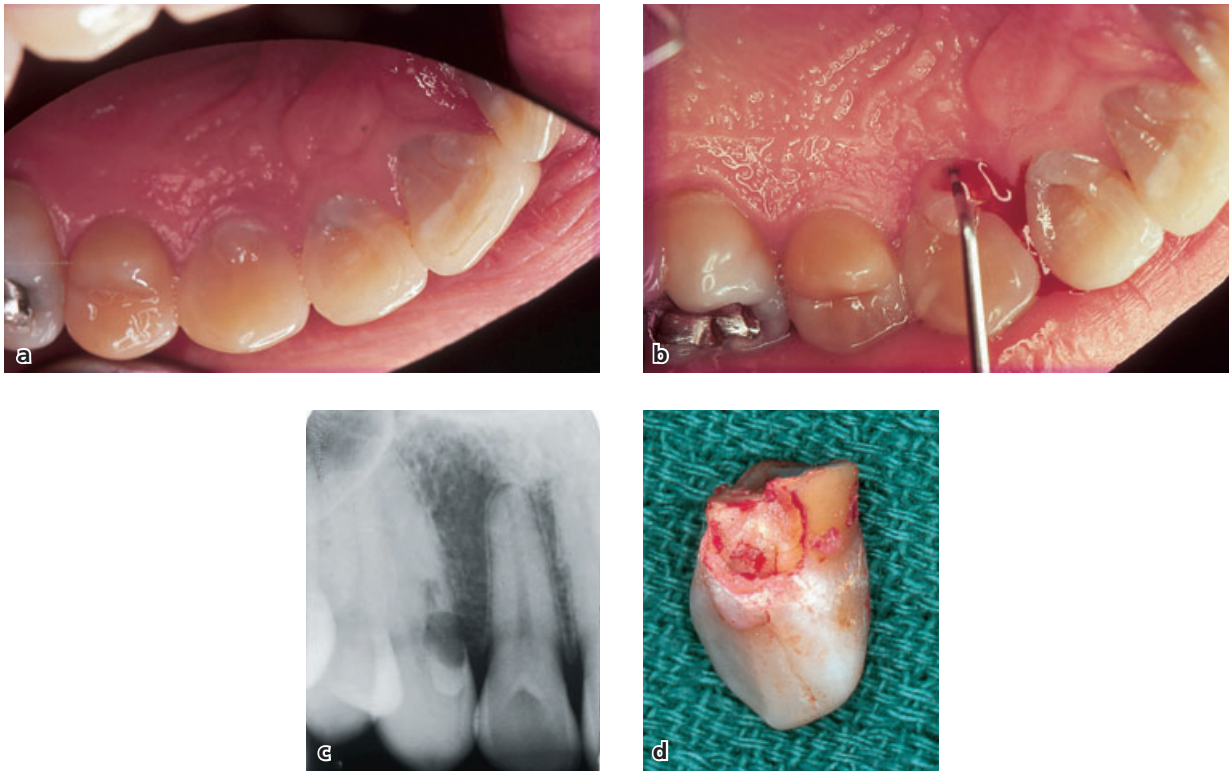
Case of peripheral inflammatory root resorption (PIRR). Pain and tenderness of the right maxilla for several weeks prompted the 30-year-old male patient to seek treatment. (a) Clinical inspection revealed no obvious pathology. (b) Periodontal probing, however, released pus drainage from the lingual aspect of tooth #13. Pulp-vitality test of the tooth as well as neighboring teeth gave clear positive responses. (c) An angulated radiograph disclosed the presence of a resorptive defect. (d) The tooth was extracted as successful treatment was deemed unlikely. An extensive resorptive defect had undermined the clinical crown.
